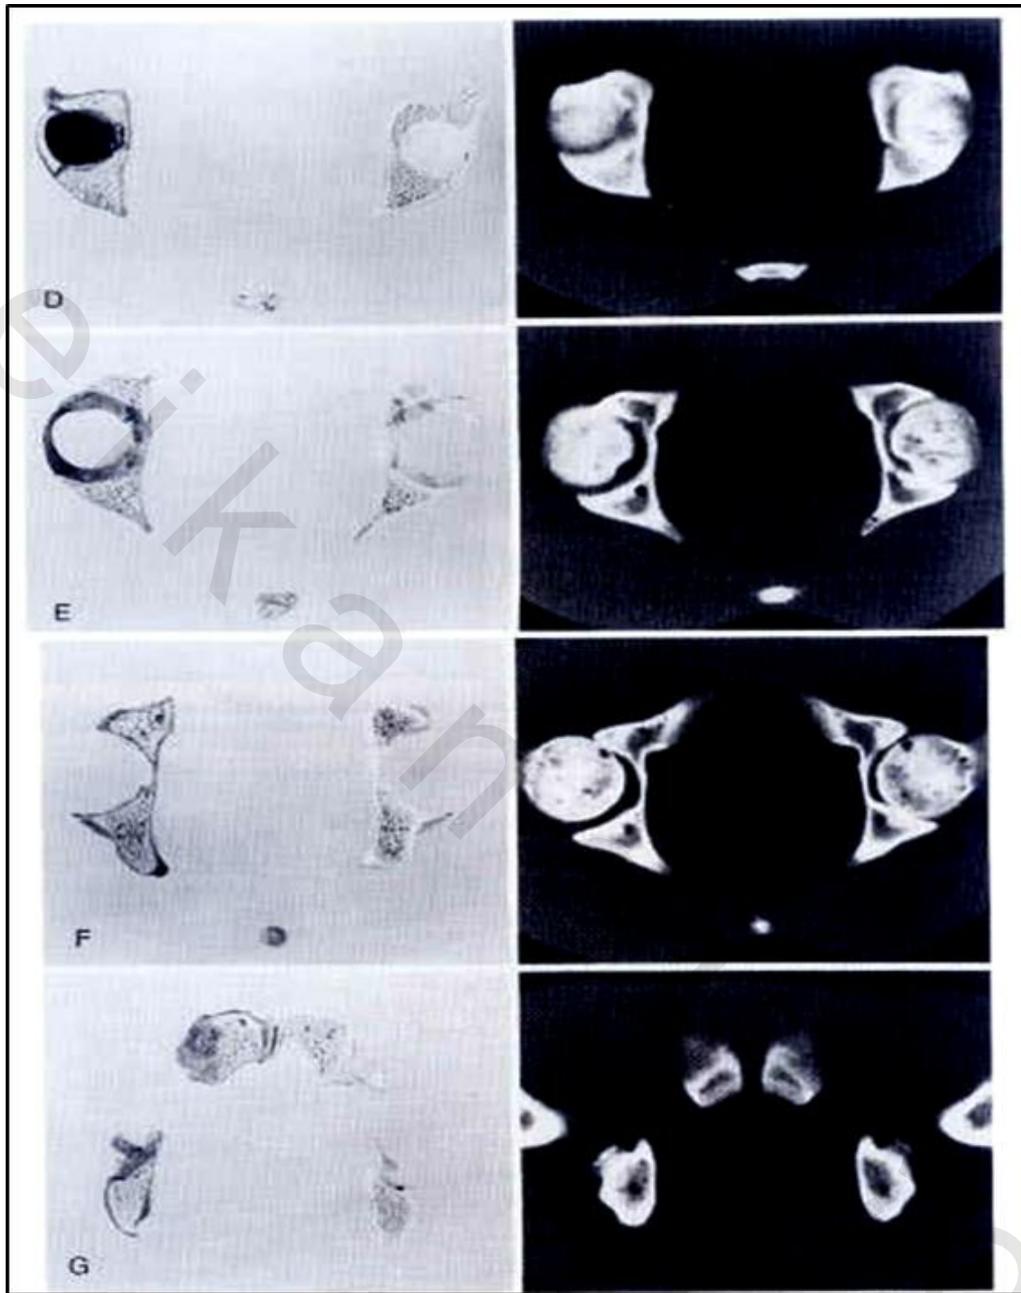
Representation of the radiograph of the pelvis seen in the Anteroposterior radiograph of the pelvis.<sup>(22)</sup>
